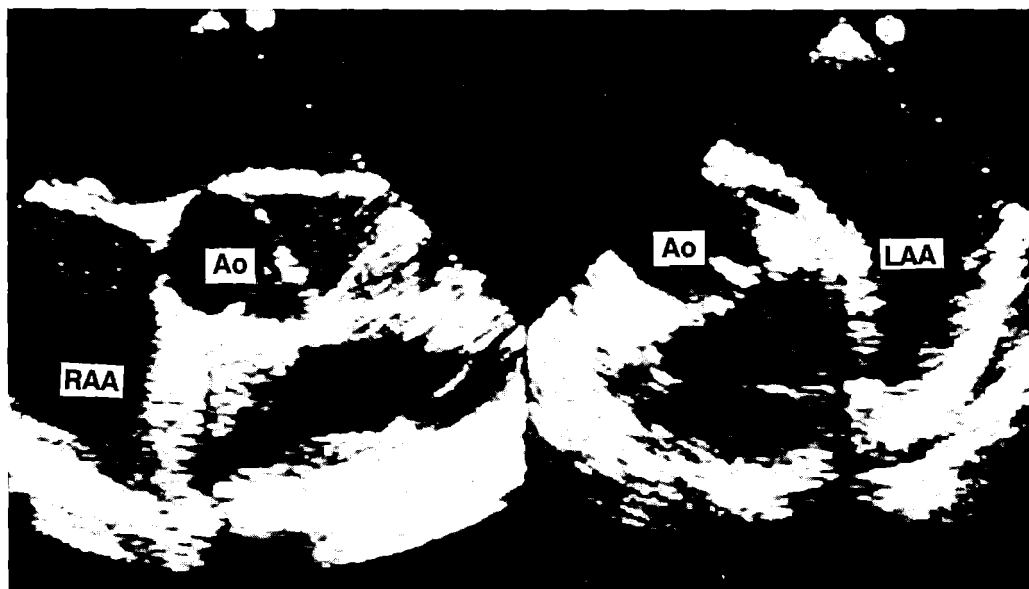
Transoesophageal study in a patient with atrial situs solitus. The unique morphologic characteristics of either atrial appendage are readily demonstrated.
